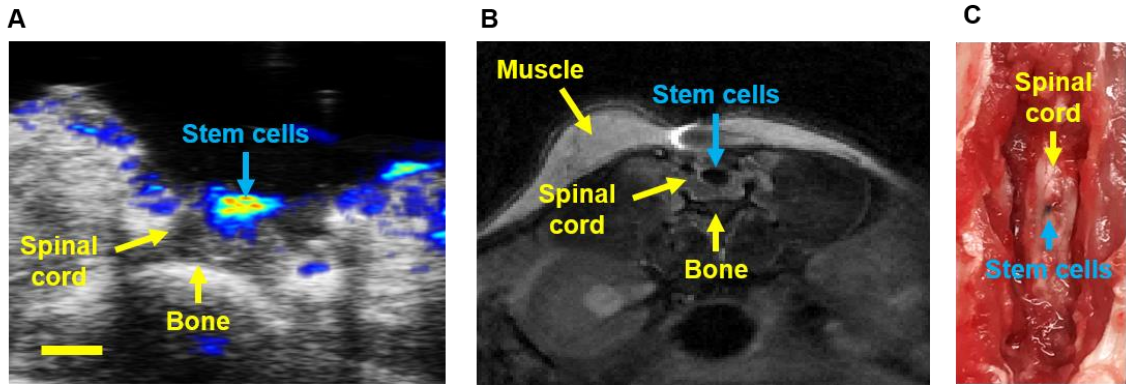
In vivo* intraoperative US/PA and post-operative MRI. (A) Combined ultrasound (grayscale) and PA (color scale) images were acquired intraoperatively with a 20 MHz transducer at 740 nm wavelength after a 5  $\mu$ l injection of PBNC-labeled MSCs at 10k cells/ $\mu$ l. Post-operative MR images were acquired 24 hours later (B). Photograph of the excised spinal cord depicting PBNC-labeled MSCs (C). Scale bar = 3 mm.
